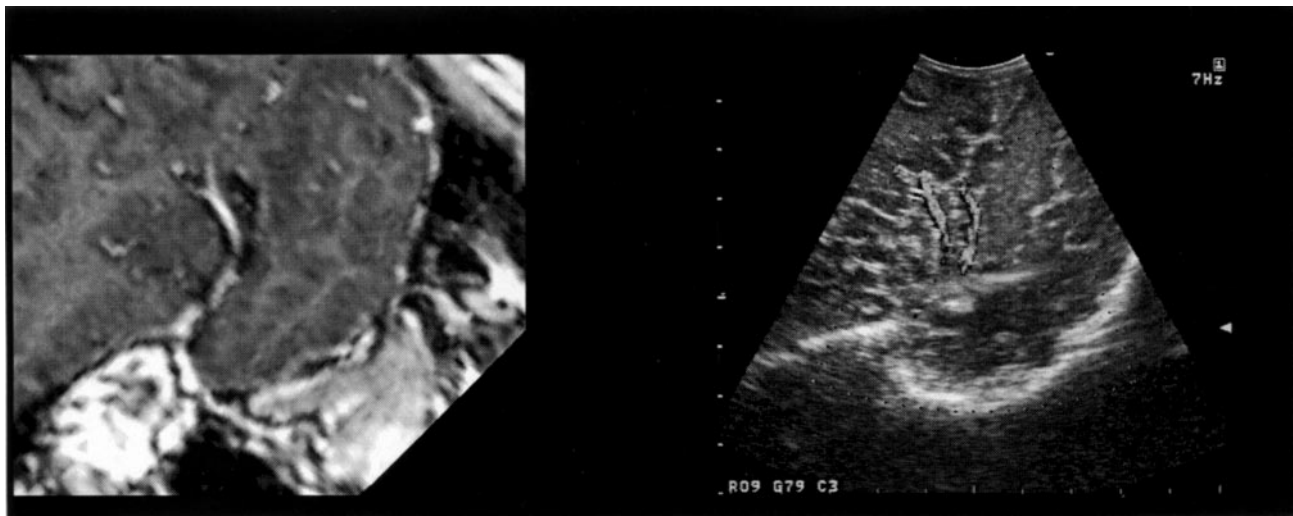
Side-by-side intraoperative ultrasound view (right) and reformatted preoperative MRI (left). Note the vessels in the Doppler ultrasound view indicated in color. These vessels can be easily detected by the system and used to track the movement of the brain during a surgical intervention, and are also easily seen on the preoperative images.
